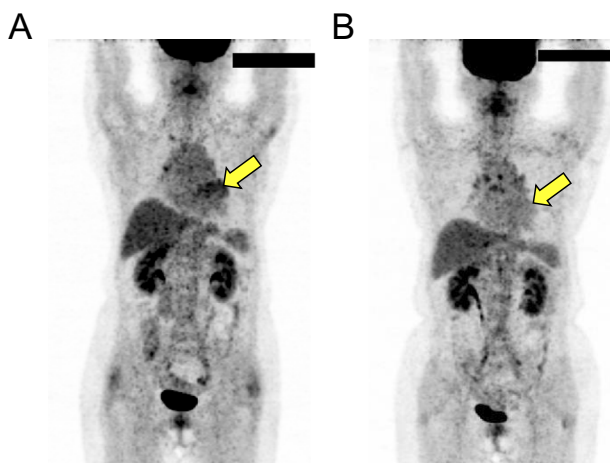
FDG-PET before (A) and after (B) additional methotrexate therapy. A: Follow-up FDG-PET at the tapering dose of 15 mg prednisolone indicated a slightly increased FDG uptake in the basal anteroseptal wall of the left ventricle (yellow arrow), suggesting reactivation of cardiac sarcoidosis. B: After one year of immunosuppressive therapy with prednisolone and methotrexate, FDG-PET showed no abnormal FDG uptake in the heart (yellow arrow).
